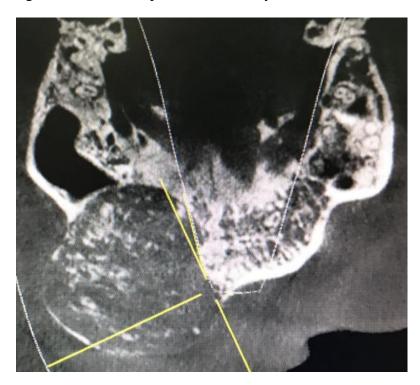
Computed tomography axial section shows a well-defined mixed hyperdense and hypodense mass and partially obliterates the right maxillary sinus).
